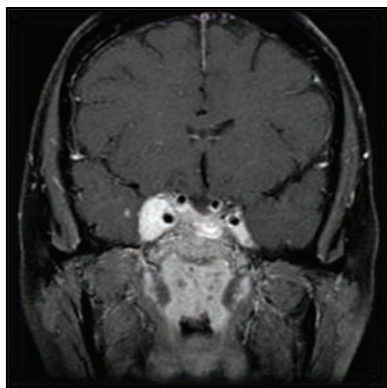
Coronal T1 weighted sequence magnetic resonance image of the brain with gadolinium contrast showing bilateral cavernous sinus involvement.
